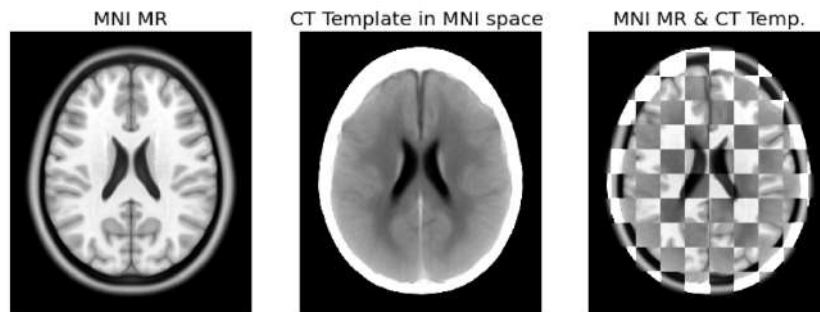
Qualitative registration results. Registration of the study-specific CT template to the MRI MNI atlas, after the second phase of iterative parameters optimisation. All registration parameters displayed in Table [A.2](#) (Appendix A)
